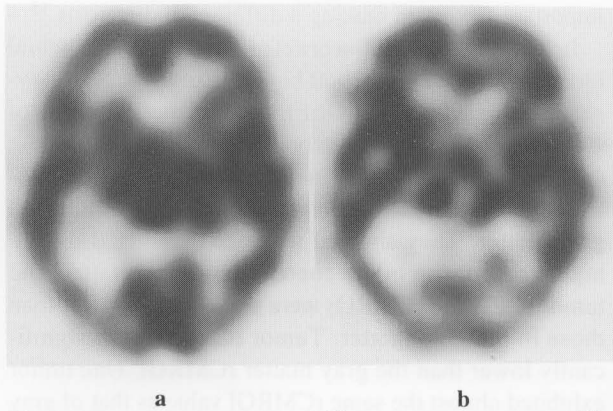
The transaxial images of ^{123}I IMP SPECT. a) Early ^{123}I IMP SPECT image showing high tumor accumulation in the right lateral ventricle and decreased accumulation in the right cerebral cortex due to the mass effect. b) Delayed ^{123}I IMP SPECT image showing decreased tumor accumulation compared to that of an early ^{123}I IMP SPECT image.
